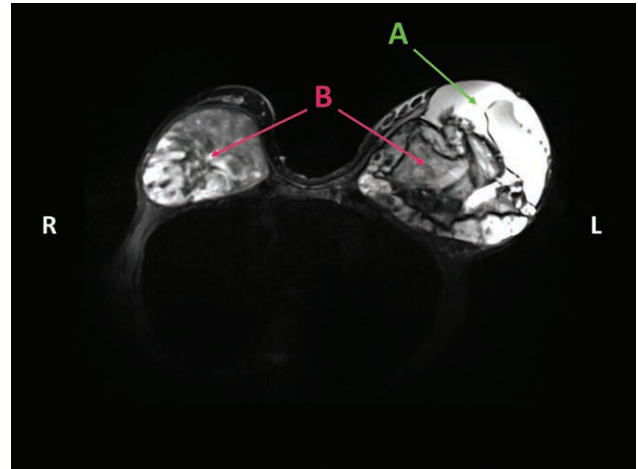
Preoperative magnetic resonance imaging demonstrating the left breast hematoma (A) and bilateral implants (B).
